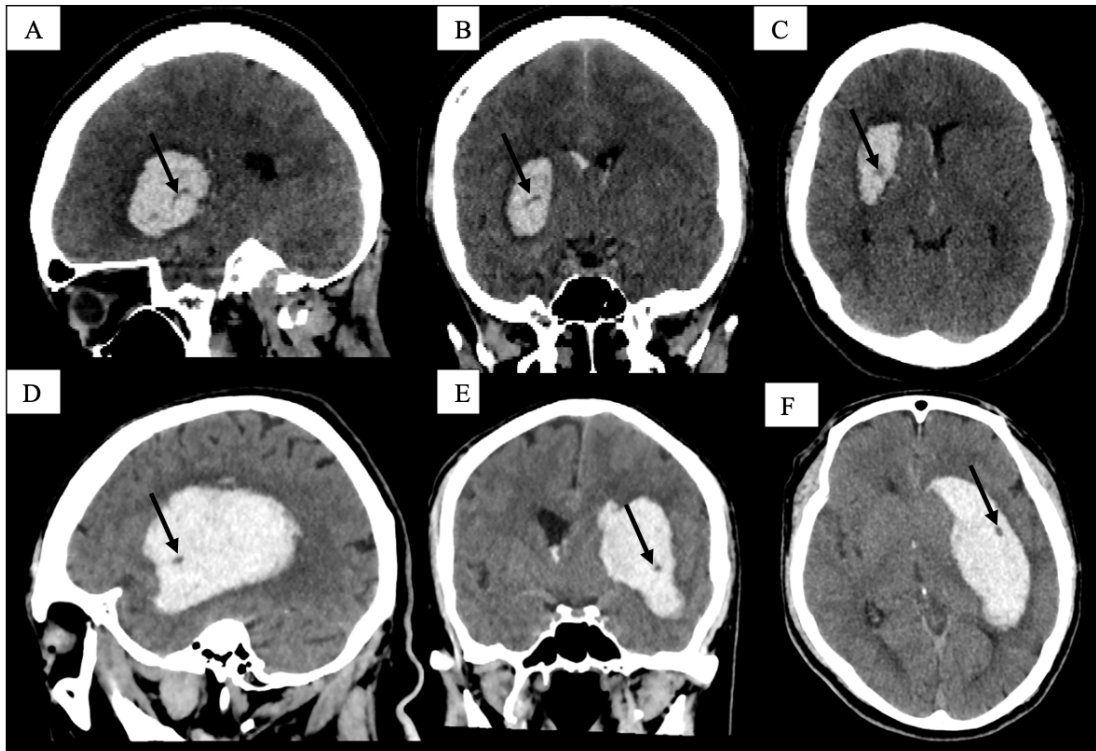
Non-contrast enhanced CT of the brain in sagittal, coronal and axial views in two different patients (A-C) and (D-F) demonstrating swirl signs in acute intracerebral haemorrhage (arrow).
